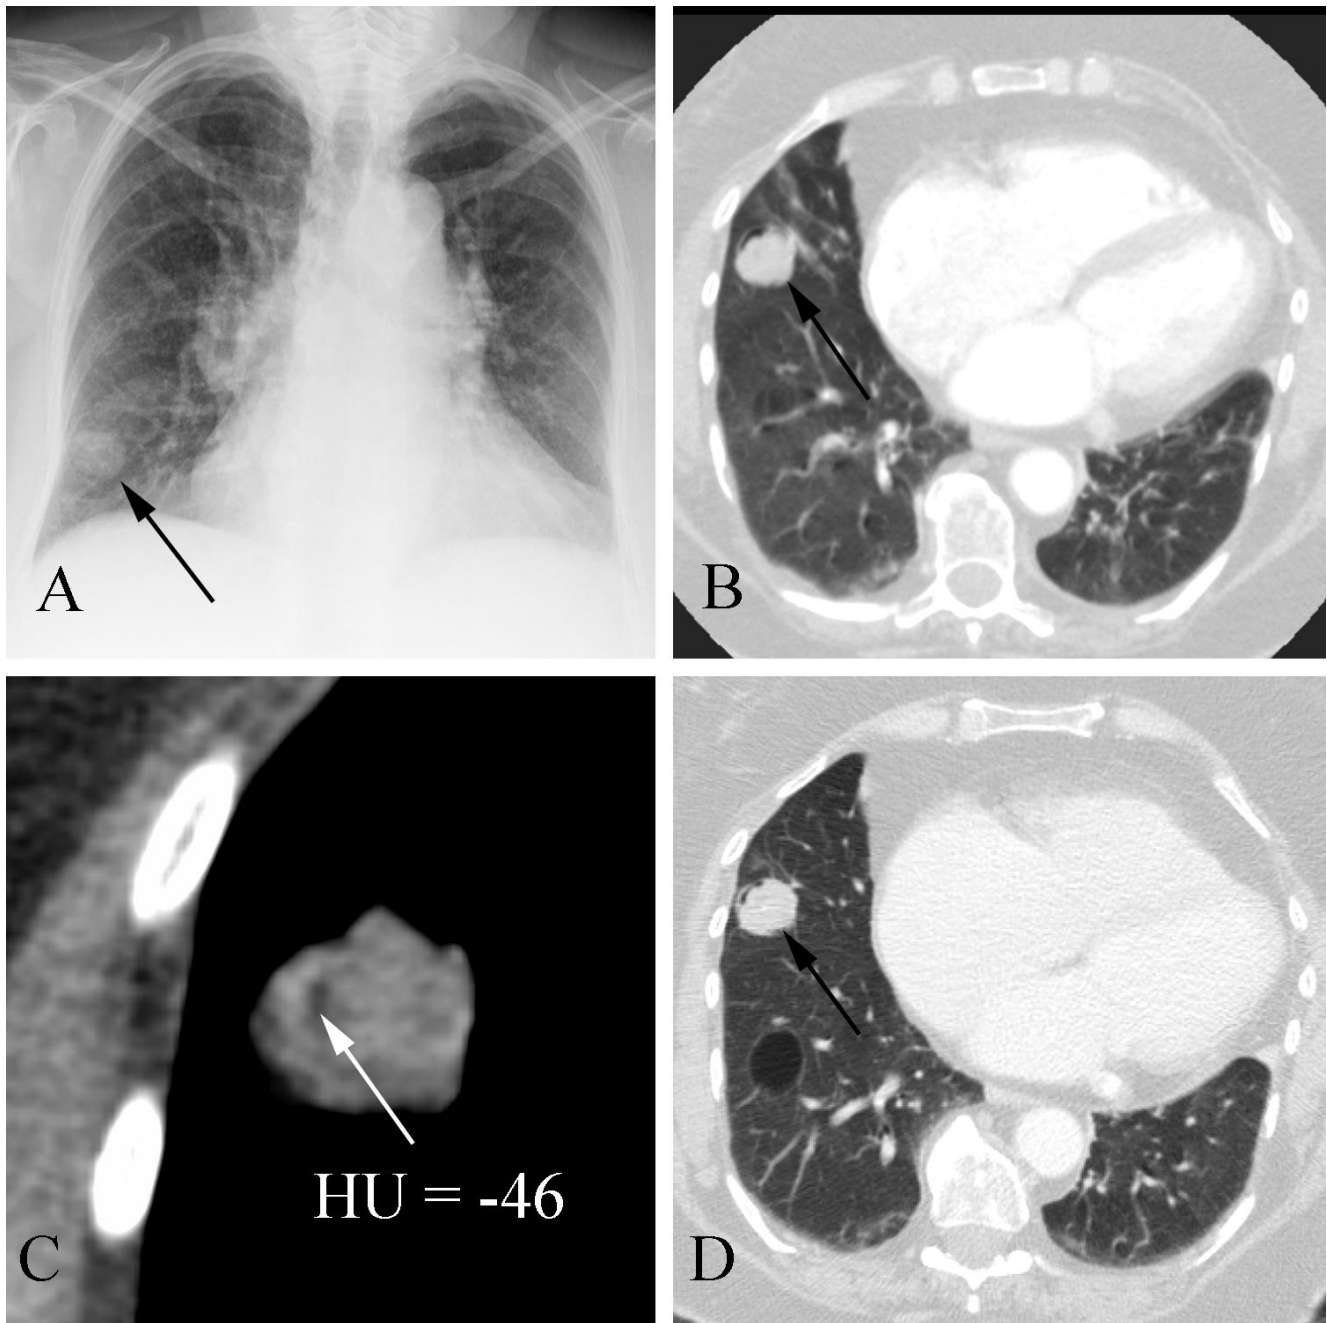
Hamartoma in a 74 year old woman with an incidentally discovered chest lesion. A. Chest radiograph obtained for shortness of breath demonstrates a lesion in the right middle lobe (arrow). B. Axial CT study filmed on pulmonary windows shows a mass (arrow). C. Magnified CT shows fat within the lesion with negative Hounsfield units indicating fat. D. Subsequent CT of the abdomen performed two years later for another reason shows that the lesion is stable.
